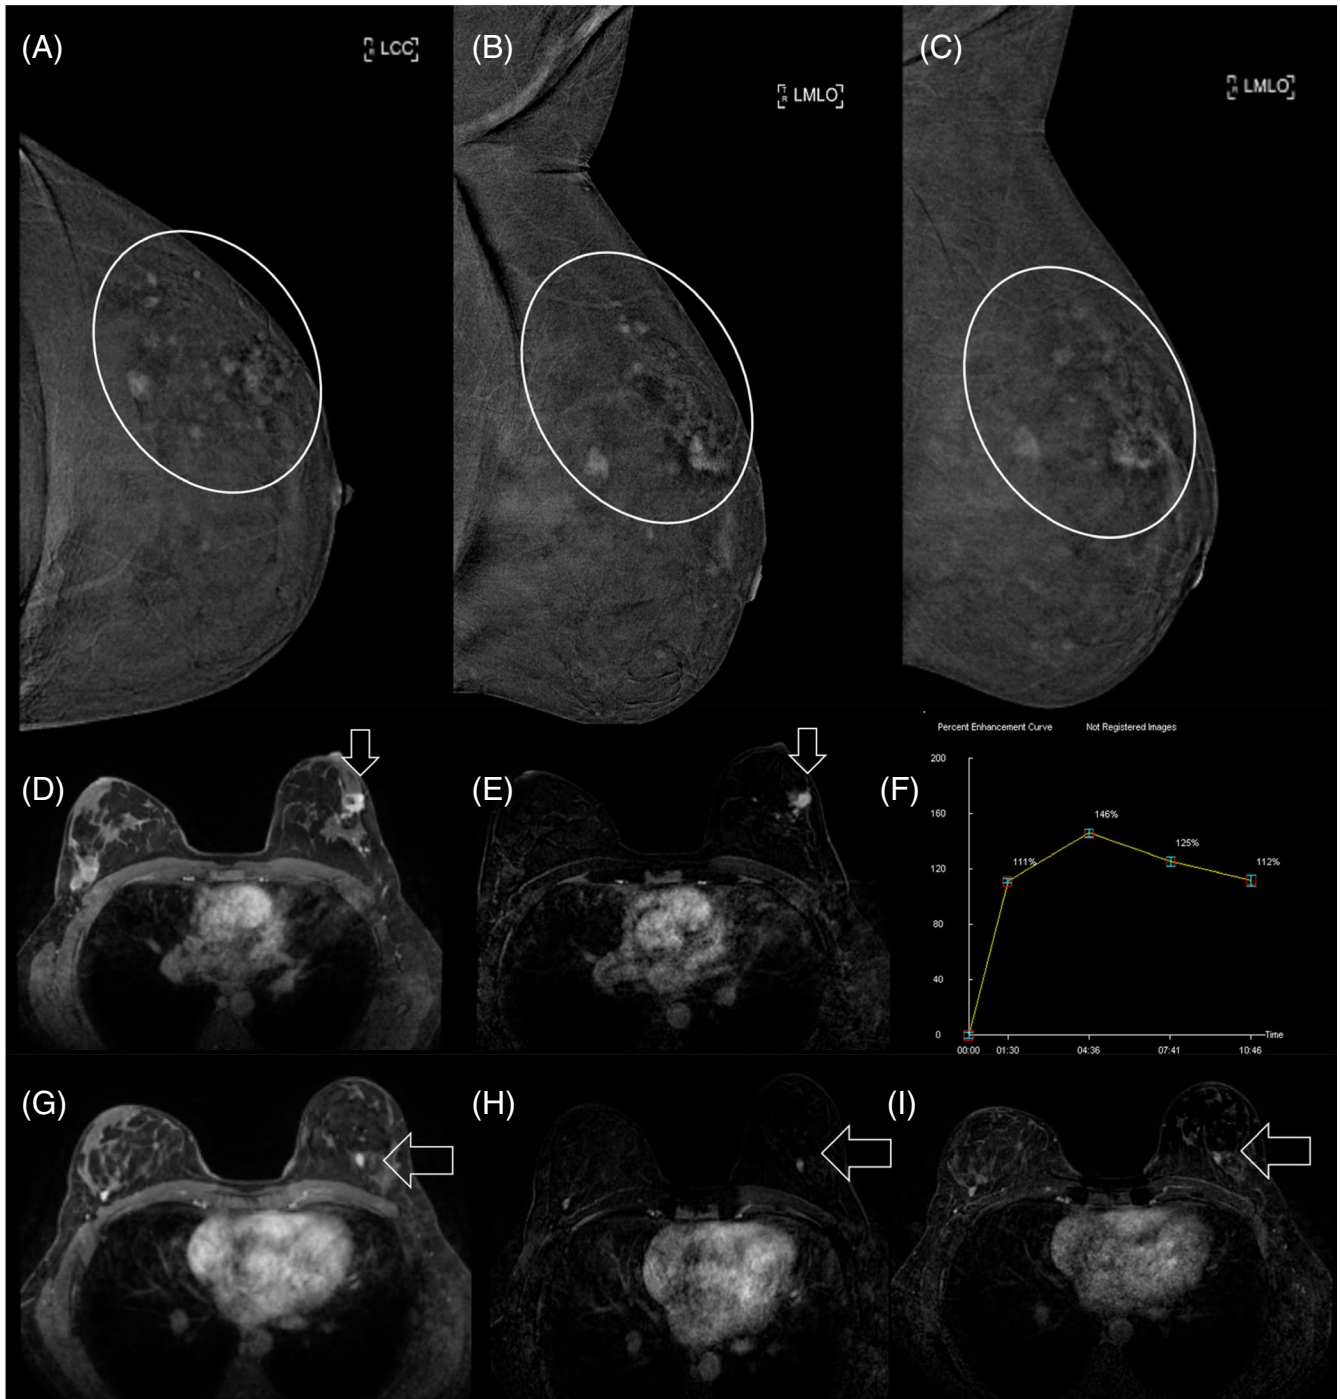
The same patient of Figures 5 and 6. Left breast CEDM. Cranio-caudal (A) and oblique (B, C) images. Multiple, enhancing tumor foci in the external upper quadrant. DCE-MRI. Multiple enhancing foci in the left breast (D, E, G, H, I). Rapid wash-in TIC with persistent enhancement (F) [Color figure can be viewed at wileyonlinelibrary.com]
